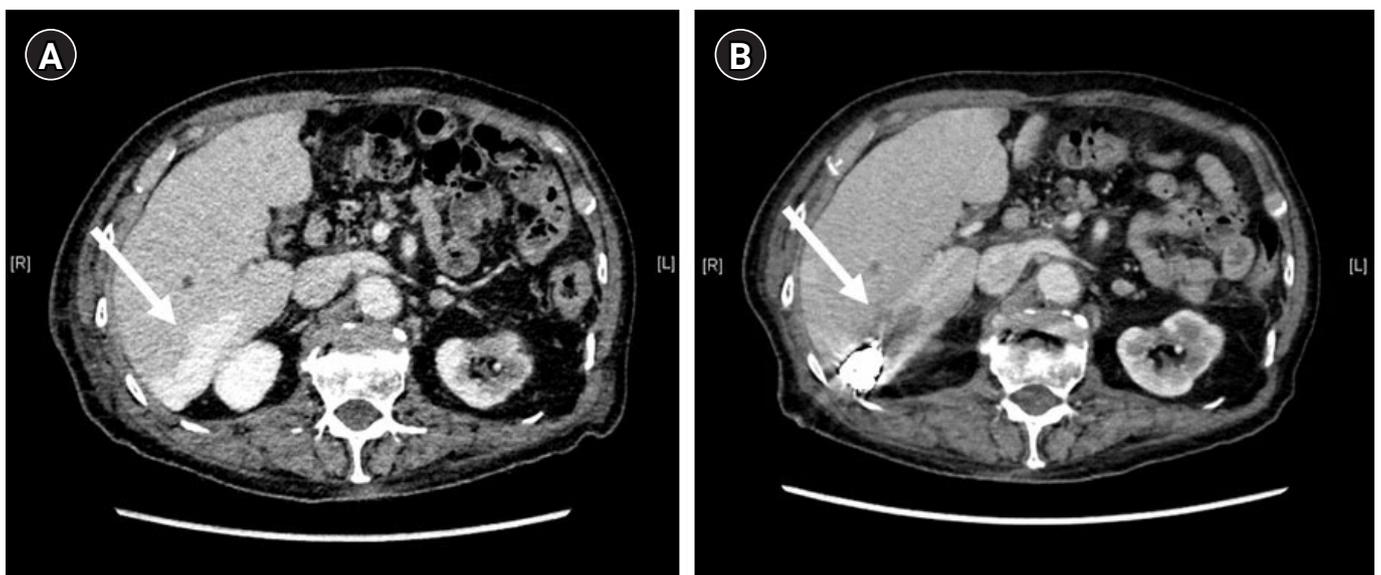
Contrast-enhanced computed tomography before and after embolization. (A) Pre-embolization (the arrow indicates a potential portosystemic shunt leading from portal vein P6 to the inferior right hepatic vein). (B) Post-embolization (the arrow indicates a thrombus from the coil embolization site to the inferior right hepatic vein, suggesting successful embolization).
